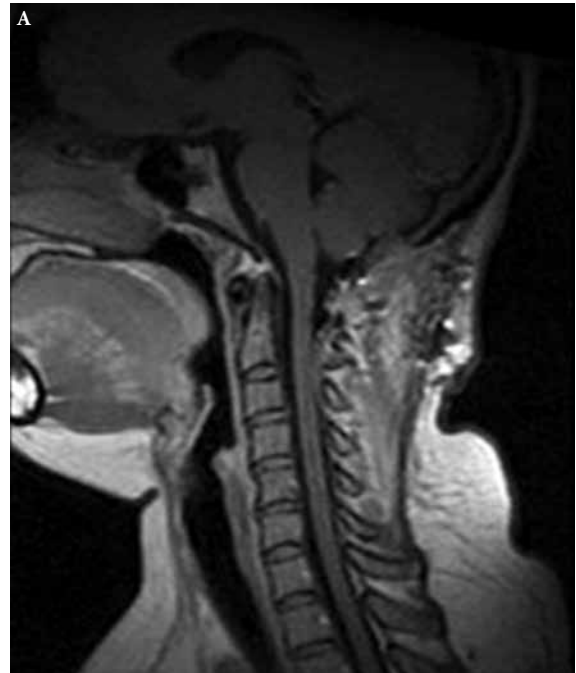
B (T1) – Weighted sagittal plane and T2-weighted axial plane MRI, respectively, showed complete resection.
